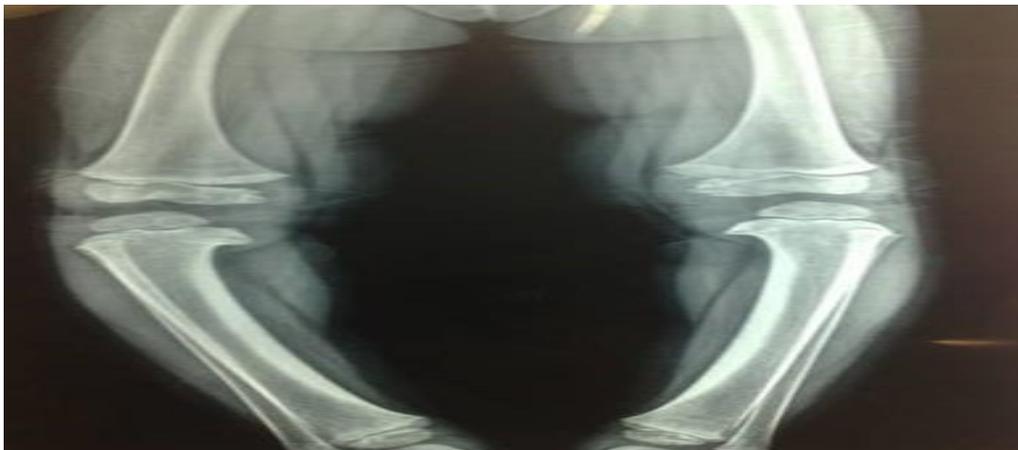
Preoperative anteroposterior X-ray view of both lower limbs with GV. ⁽³⁾
